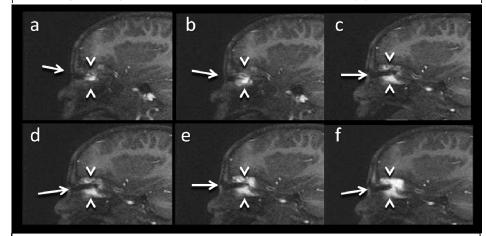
Sequential image captures from MRI fluoroscopic monitoring of the injected sclerosing agent during treatment of the veno-lymphatic malformation shown in figure 1. Tri-orthogonal plane guidance is being implemented utilizing FLASH sequence (TR/TE,2484/5,4). The shown images are from a sagittal oblique plane obtained along the injecting needle (arrows, a-f). The sclerosing material is mixed with dilute gadolinium to facilitate monitoring of distribution during treatment (arrowheads, a-f). Two additional orthogonal planes (not shown) are routinely acquired to facilitate accurate mapping of the injected volume in relation to the malformation and to critical orbital structures.
